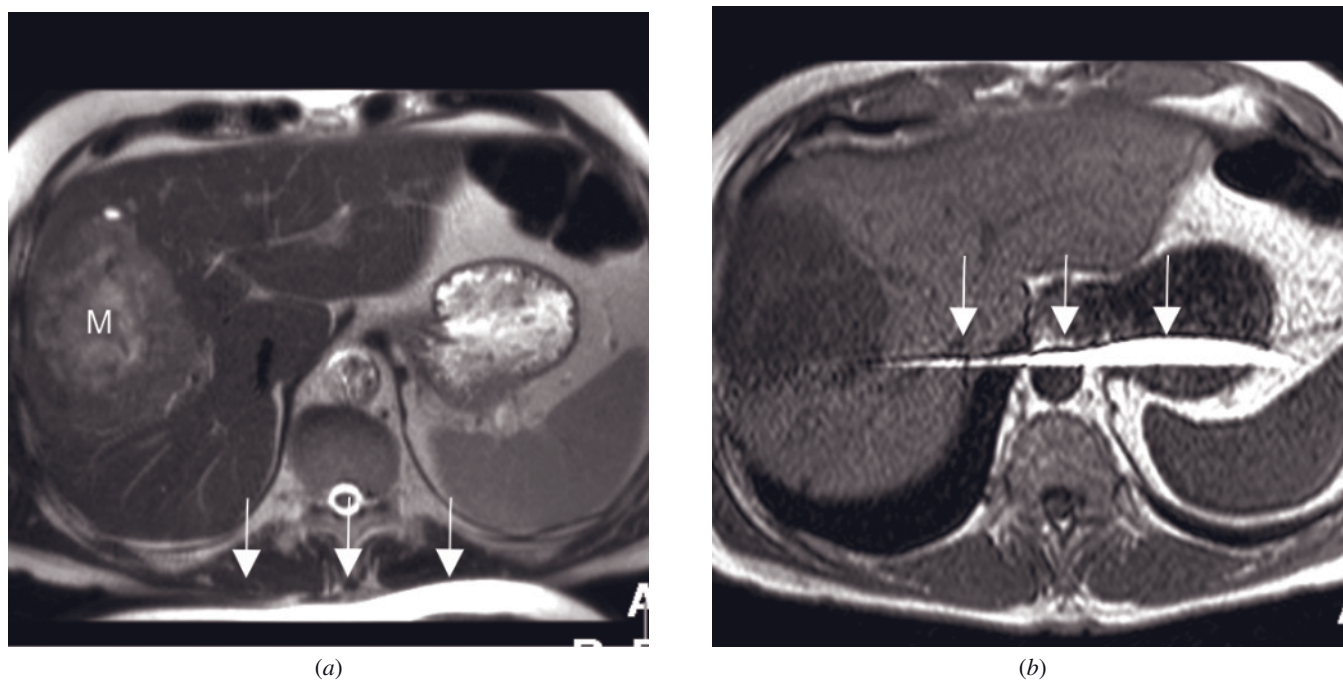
Aliasing (foldover artifact) with and without parallel imaging. Axial T2-weighted single-shot echo-train spin-echo image without pMRI (a) shows the foldover artifact originating from the anterior abdominal wall projected on the opposite side of the image (arrows). A large metastasis is present in the liver (M). Axial SGE image with parallel imaging acceleration factor 2 (b) shows the foldover artifact projected in the center of the image (arrows).
